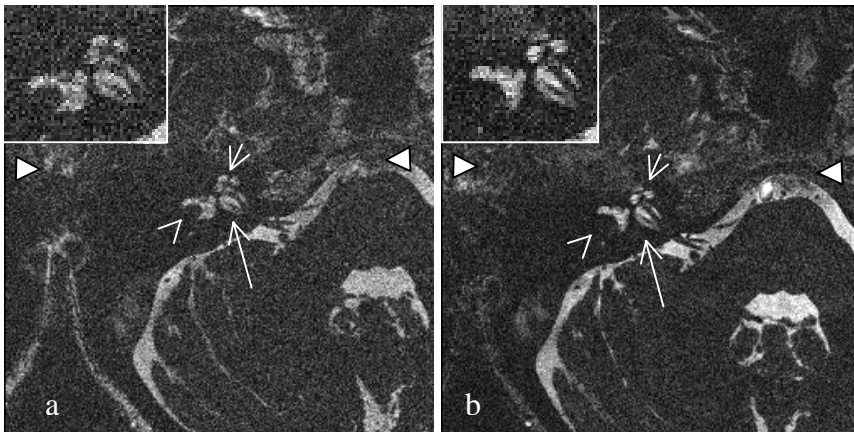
MR images (CISS sequence) of a normal right inner ear. Comparison of axial slices of the same ear and slice position (thickness: 0.4 mm,) obtained after a measuring time of 7:37 min with 1.5 T (a) and 3 T (b). The cochlea (short arrow), the semicircular canal (arrow head) and the vestibulocochlear nerve (long arrow) are seen in the central image region. The pulsation artifact from the carotis interna extends between the two triangles. A magnification of the inner ear region is shown in the upper left of the respective image.
